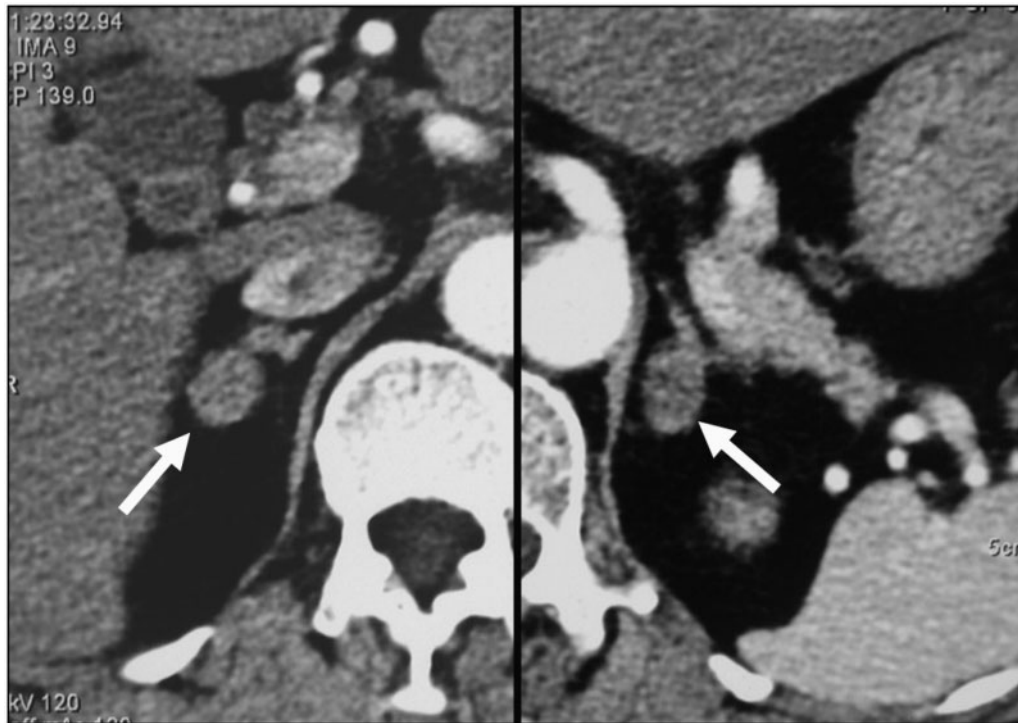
CT scan demonstrating bilateral aldosterone-producing adenomas (arrows) in patient 3, in whom the adenomas were found simultaneously.
